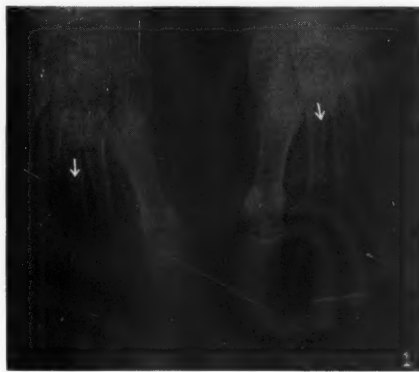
X-ray of the feet of a woman aged 30 years, who had had 'idiopathic' steatorrhoea for 12 years. Serum phosphorus, 1.0 mg. per 100 c.c., serum calcium, 8.7 mg. per 100 c.c. Note demineralization and multiple translucent zones in the metatarsals.
